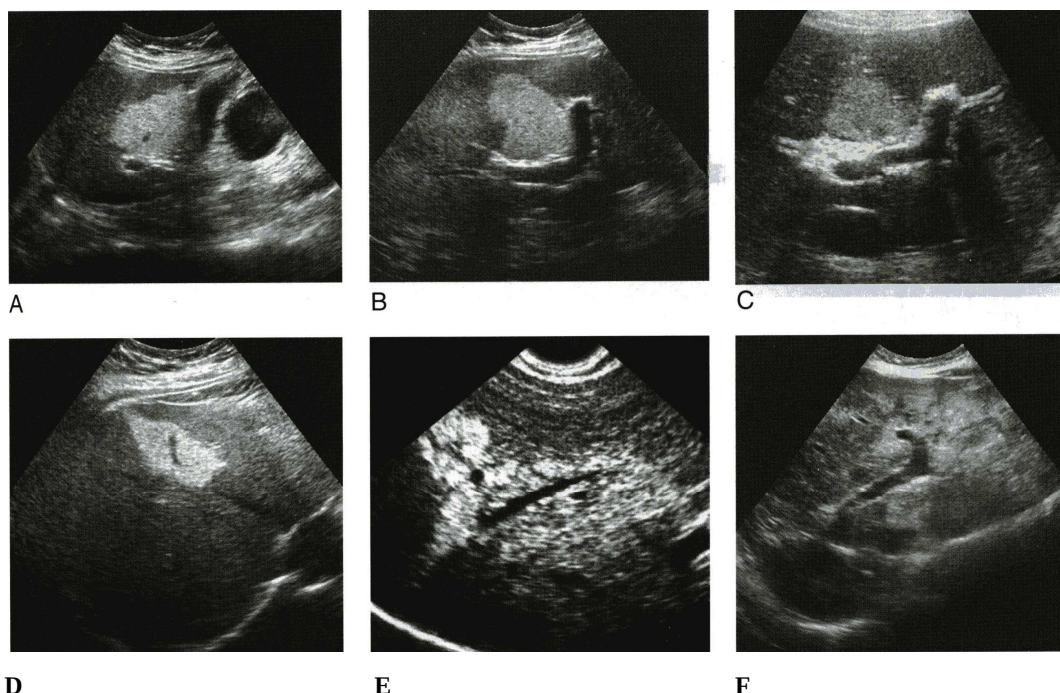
A,B,C,D,E&F showing ultrasound images of focal fat- spectrum of appearance (Rumak et al 2005)
